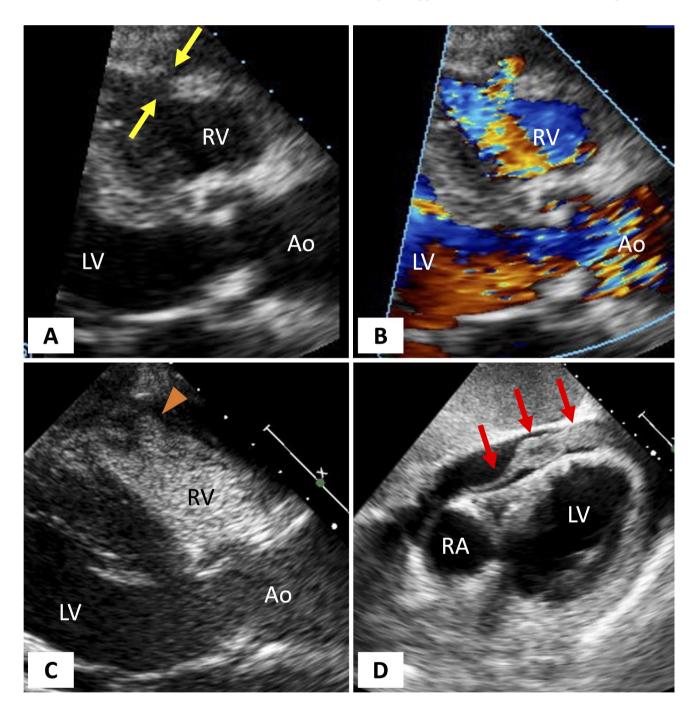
A, B Transthoracic echocardiogram showing right ventricular free wall rupture (*yellow arrows*) with color Doppler demonstrating flow through the defect. C With the injection of agitated saline, microbubbles can be seen passing through the right ventricular wall
